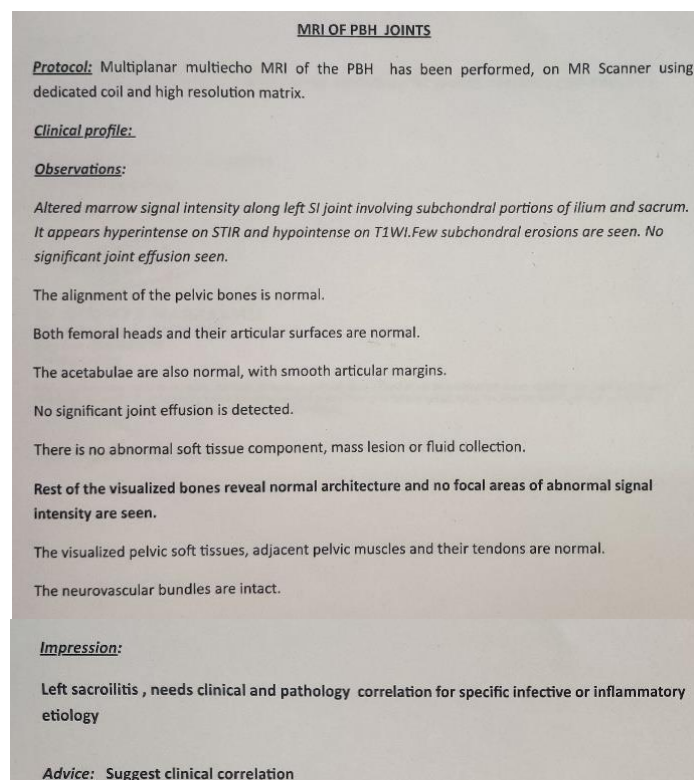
The report of the MRI of the hip joint.
